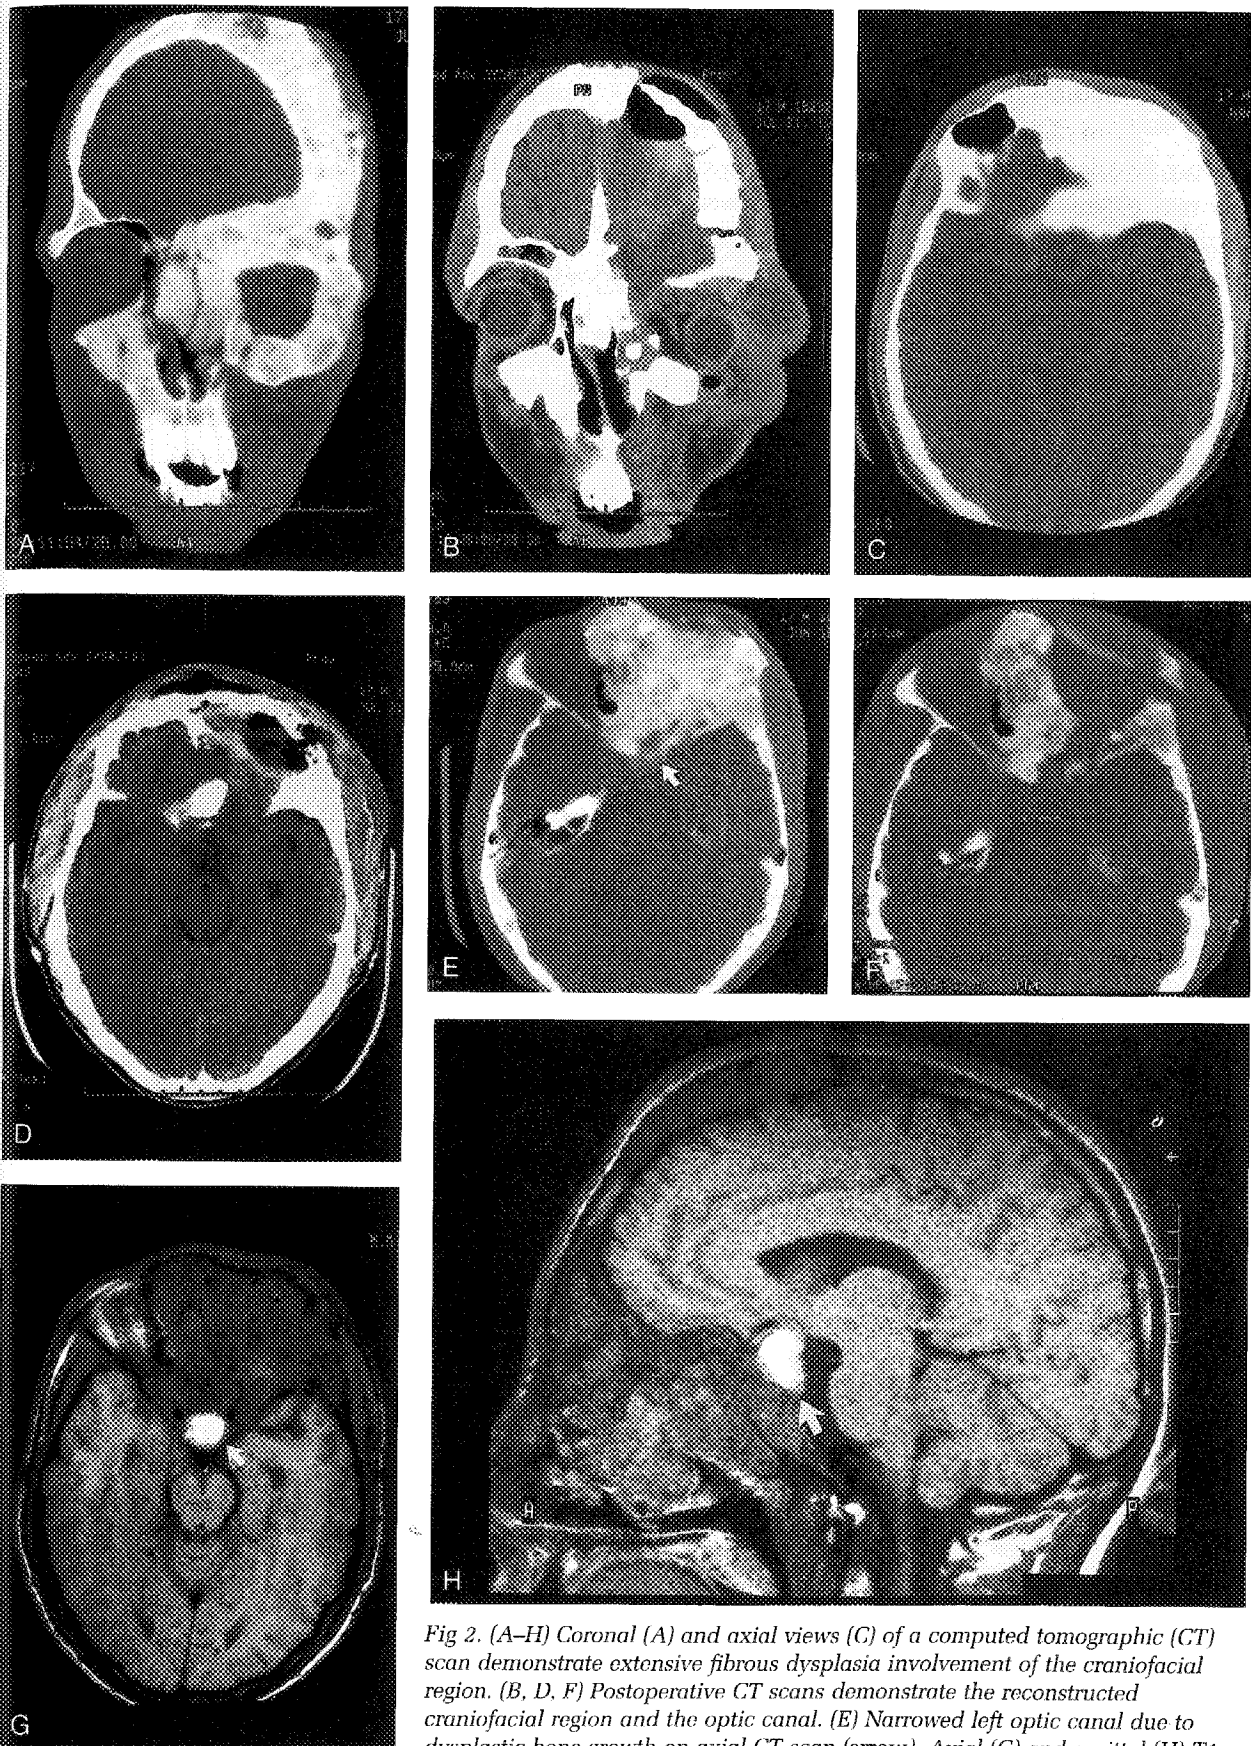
(A-H) Coronal (A) and axial views (C) of a computed tomographic (CT) scan demonstrate extensive fibrous dysplasia involvement of the craniofacial region. (B, D, F) Postoperative CT scans demonstrate the reconstructed craniofacial region and the optic canal. (E) Narrowed left optic canal due to dysplastic bone growth on axial CT scan (arrow). Axial (G) and sagittal (H) T1-weighted magnetic resonance images demonstrate the pituitary adenoma (arrow).
